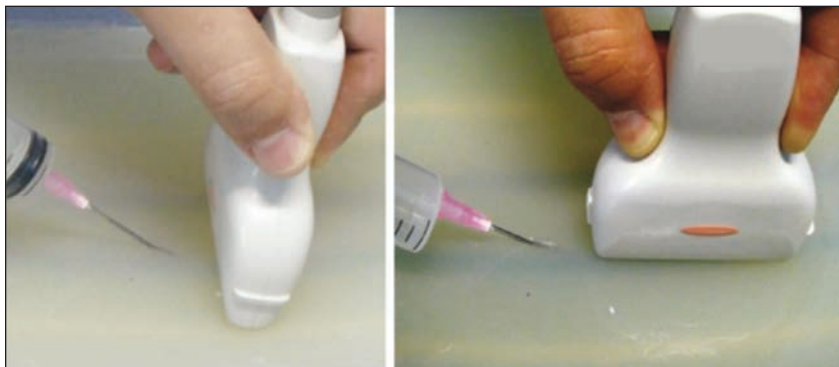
Ultrasound Guided Injections—Top Left: Indirect or out of plane approach. Reveals a small transverse hyperechoic image of the needle. Top Right: Direct or in plane approach provides a longitudinal hypoechoic view of the needle in the ultrasound field.
